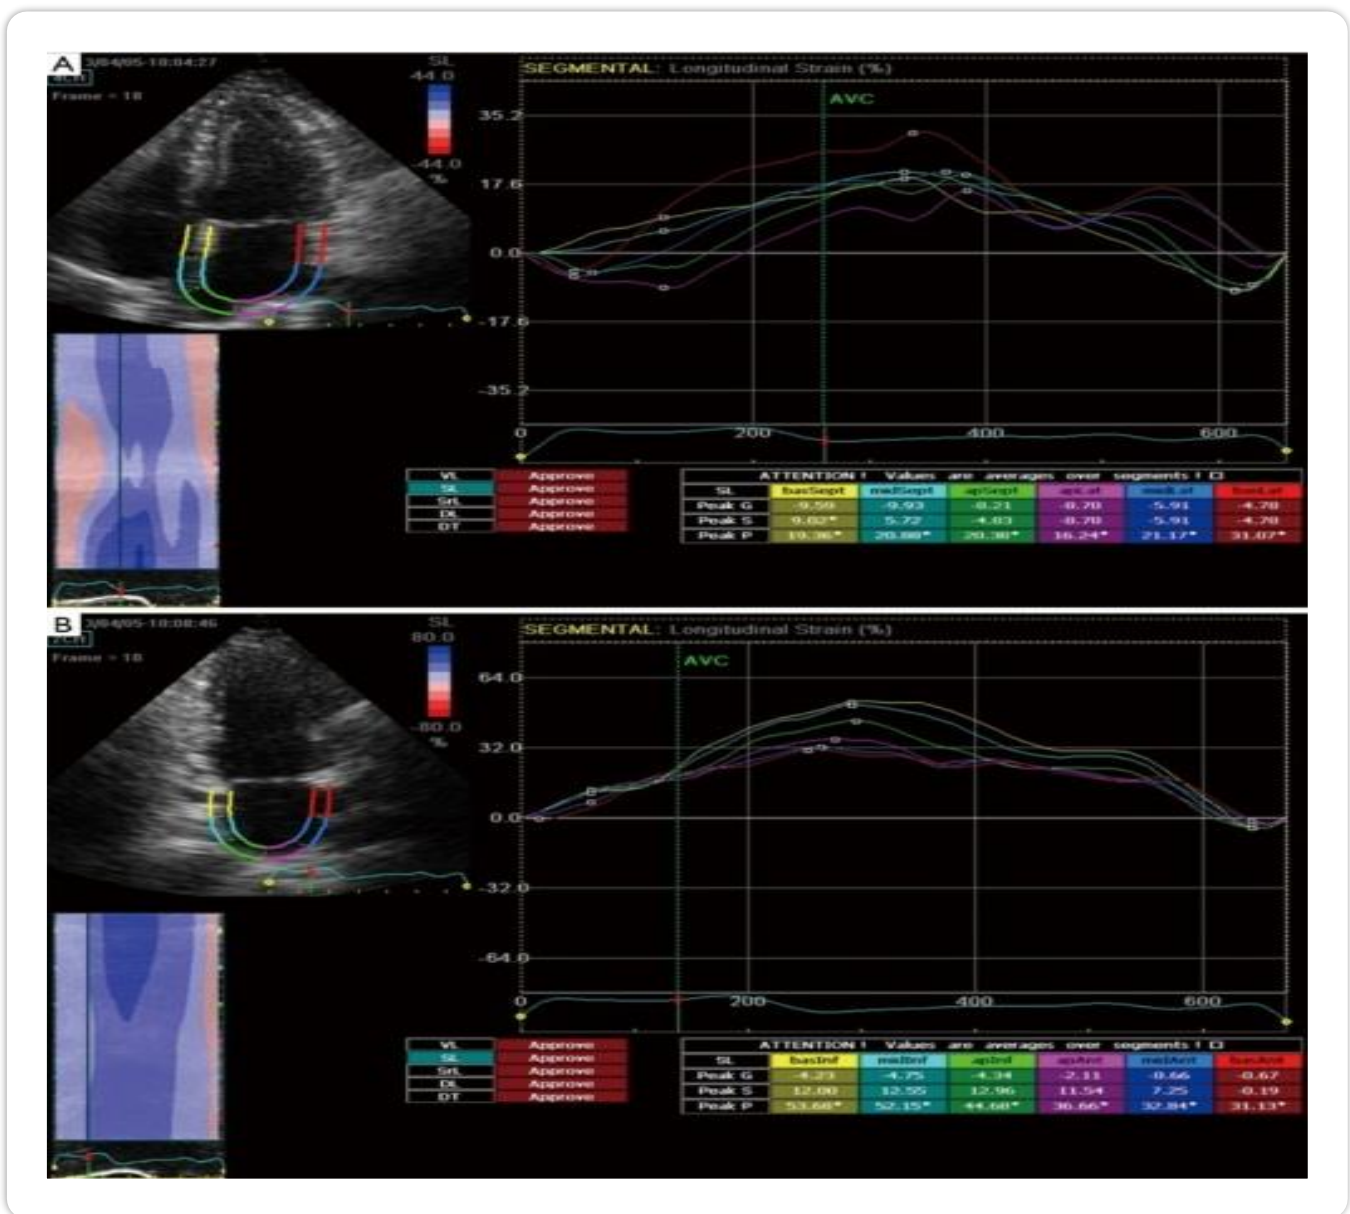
Segmental and global left atrial (LA) strain as measured by two-dimensional speckle-tracking echocardiography [27].
